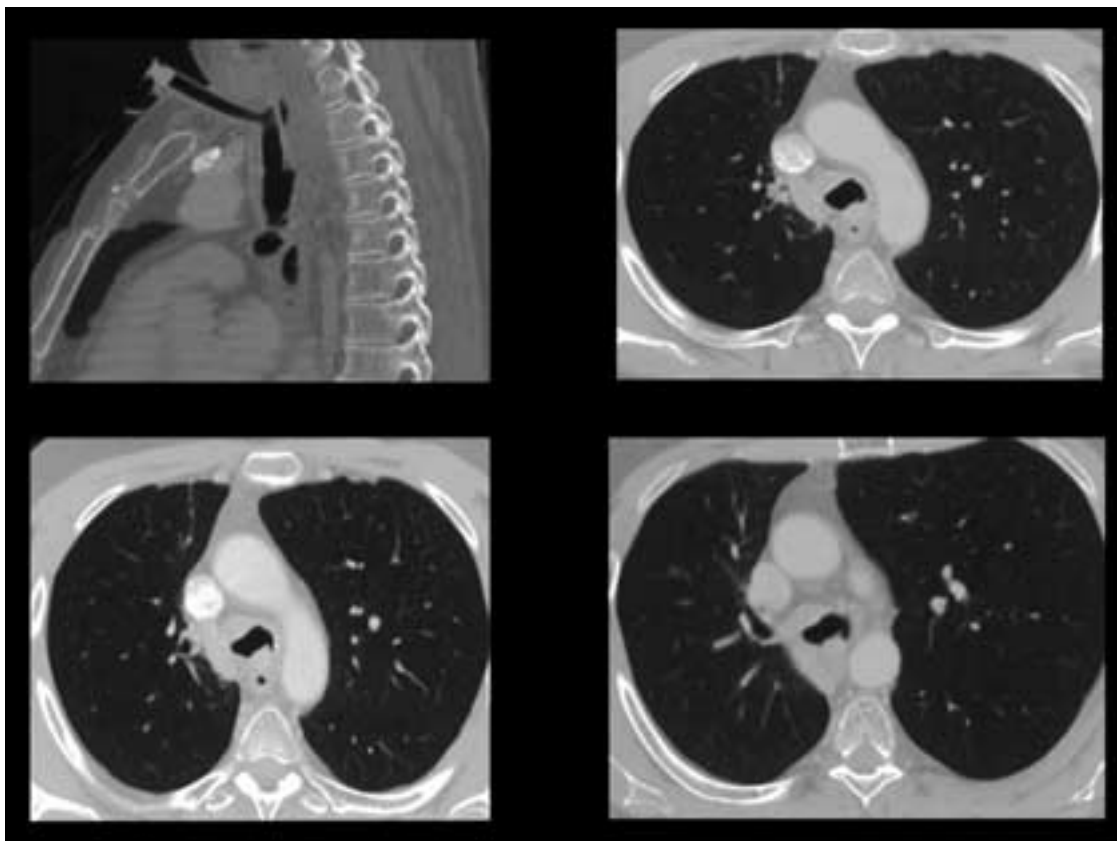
Glomus tumor. An 86-year-old male with episodic shortness of breath, cough, and hemoptysis. Rigid bronchoscopy and biopsy revealed multiple tracheal nodules and tracheal thickening. Biopsy demonstrated glomus tumor. Sagittal reconstruction of a contrast-enhanced CT scan demonstrates a tracheostomy tube that extends to the level of the transverse aorta (upper left corner). Diffusely thickened soft tissue with nodular components encases the trachea (remaining panels).
